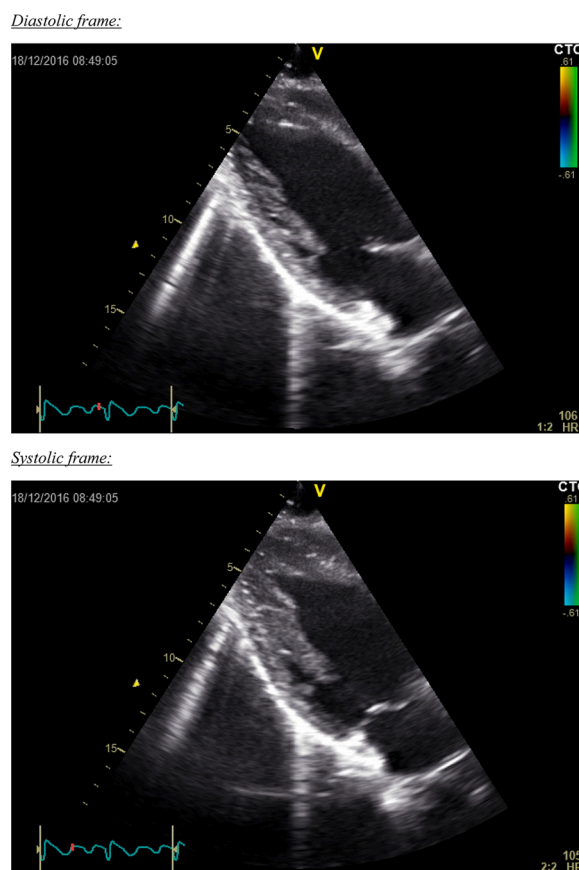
Transthoracic cardiac ultrasound.
